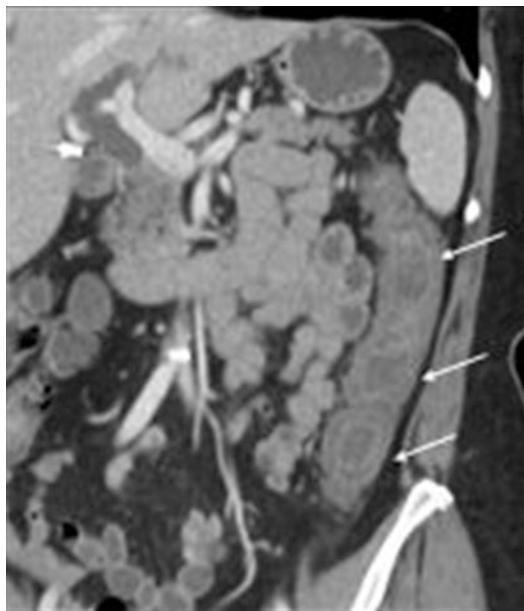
Ischemic colitis causing left lower abdominal pain. Coronal abdominal CT image with intravenous contrast shows wall thickening in the descending colon (arrows) in a recently hypotensive 80-year-old patient. Although the submucosal edema is non-specific, ischemic colitis was diagnosed endoscopically
